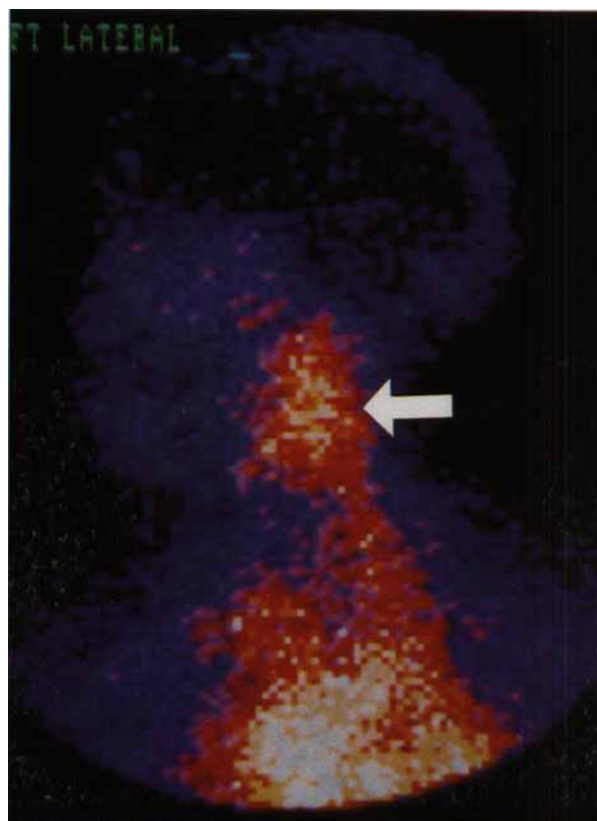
A positive immunoscintigram (left lateral view) of a patient with pleomorphic adenoma on the left side.
